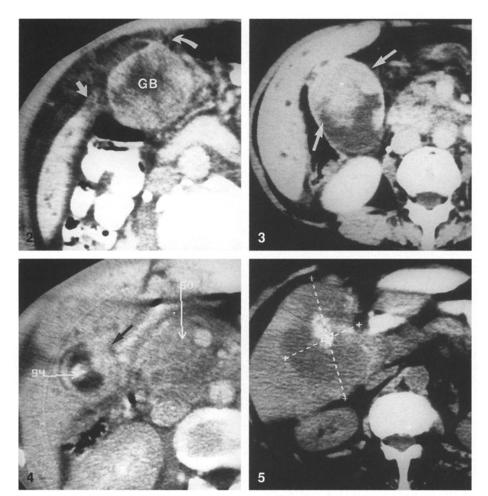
Gallbladder carcinoma, type 1. CT scan demonstrates a soft tissue mass enlarging and almost completely filling the gallbladder lumen (GB). Liver involvement is seen adjacent to the mass (straight white arrow). Streaky densities extending to the abdominal wall suggest contiguous spread (curved white arrow).
